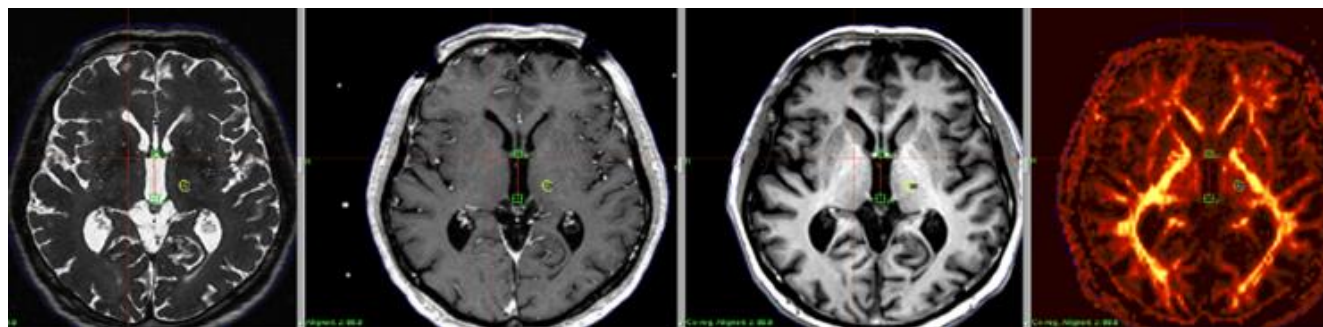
Localization of the target (VIM) and areas at risk (internal capsule) using several MRI modalities. Respectively from left to right, 1.5T T2 thin slice MRI, 1.5T T1 MRI, 3T T1 MRI, 3T DTI MRI.
